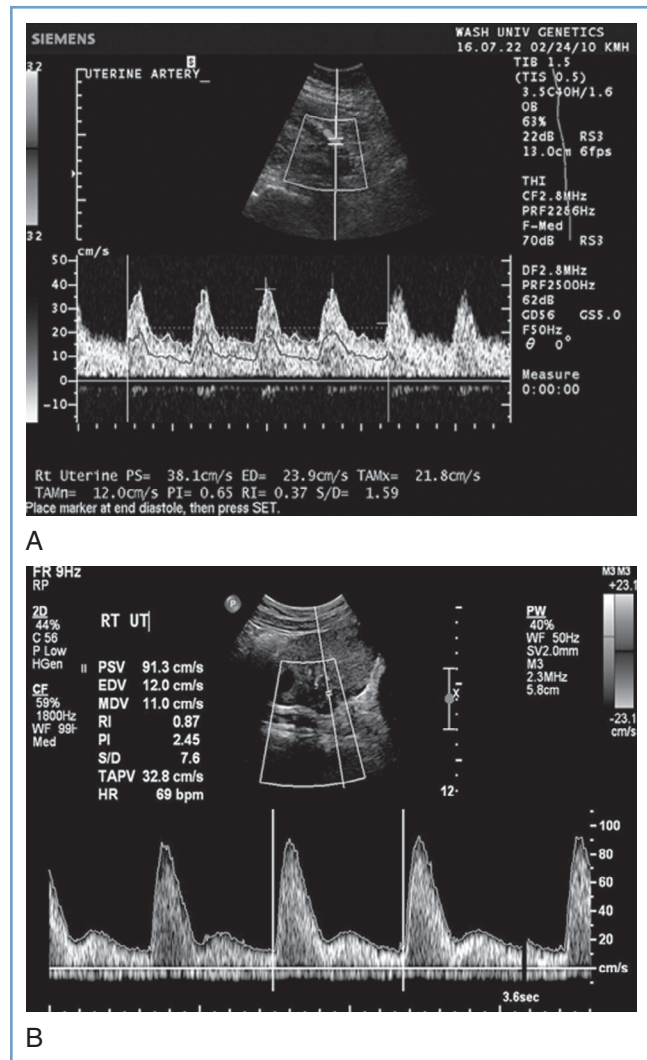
■ Normal (A) and abnormal (B) uterine artery Doppler waveforms. The normal waveform has no notching and normal pulsatility. The abnormal waveform shows notching and increased pulsatility. (From Tuuli M, Odibo AO. The role of serum markers and uterine artery Doppler in identifying at-risk pregnancies. *Clin Perinatol* 2001; 38:1-19.)
